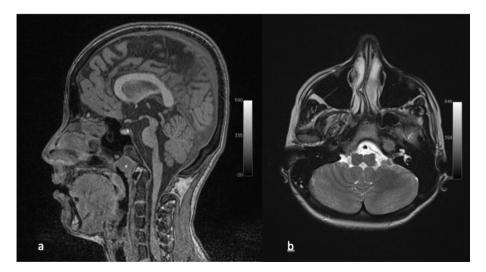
Conventional MRI: (a) T1-weighted 3D sagittal images demonstrate the hypoplastic pons and medulla, (b) Axial T2-weighted slices show a prominent midline cleft and the resulting characteristic "butterfly" configuration.
